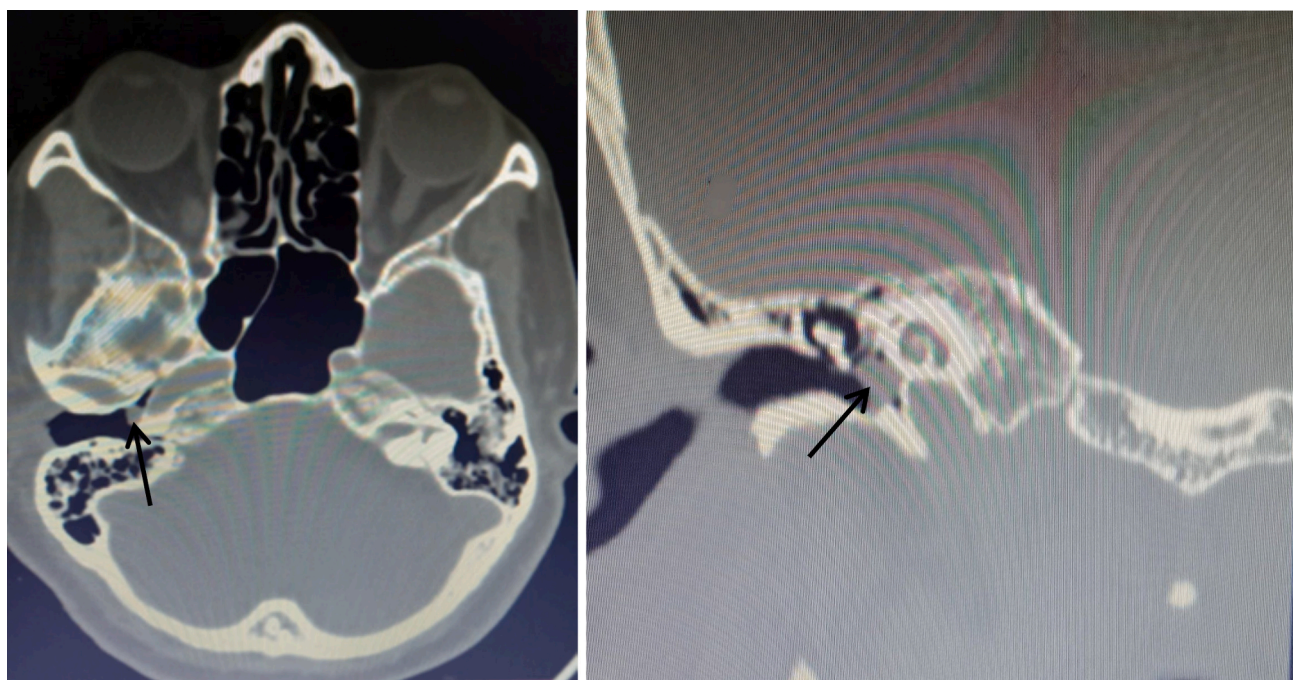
Temporal bone CT scan with contrast showed right side 7 mm * 5 mm soft tissue density homogeneously enhancing mass just behind the tympanic membrane on the promontory with small extension to Eustachian tube area (solid arrows).
